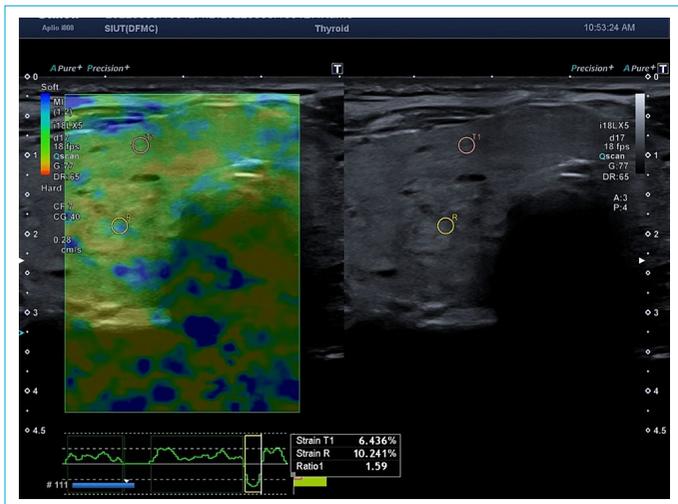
Ultrasound strain elastography image performed with superficial linear probe on thyroid nodule with heterogenous morphology texture and irregular margins having strain ratio of 1.59. According to the cut-off value of 2.32, this will qualify as negative for malignancy.
